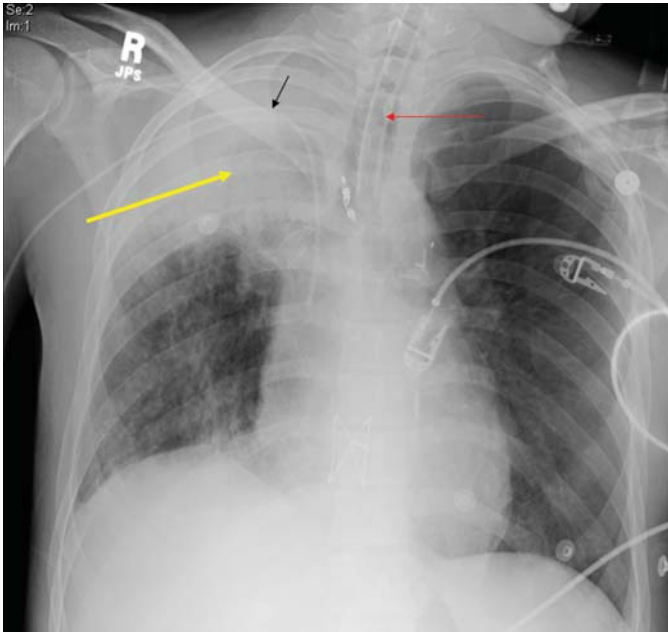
FIGURE e24-7 Chest x-ray (CXR) demonstrating right upper lobe collapse (yellow arrow). Note the volume loss as demonstrated by the elevated right hemi-diaphragm as well as mediastinal shift to the right. Also apparent on the film are an endotracheal tube (red arrow) and a central venous catheter (black arrow).
